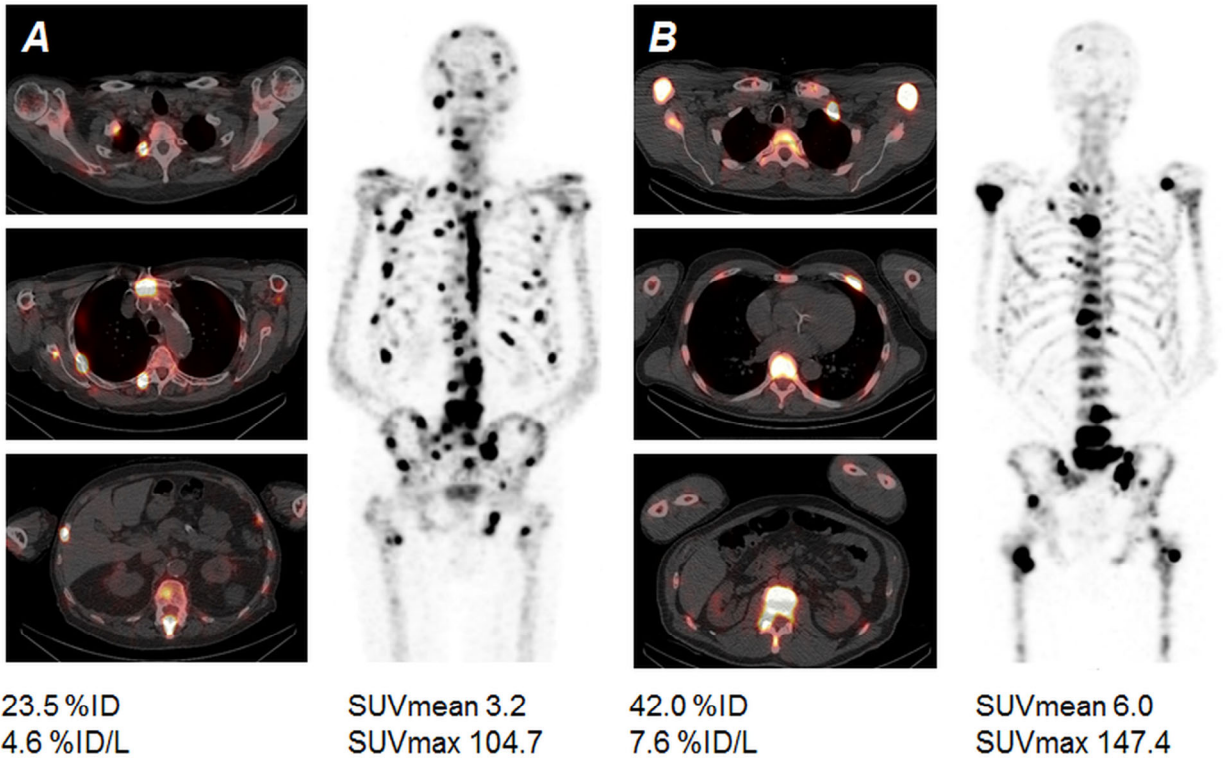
Typical case studies in two patients with disseminated bone metastasis. Quantitative SPECT/CT revealed low to moderate parameters of ^{99m}Tc -DPD uptake except for pronounced SUVmax in patient A [left] while all measures were markedly high in patient B [right]. Both patients subsequently received 6 cycles of ^{223}Ra . OS survival in patient A (85 y) was 13 months while patient B (72 y) only survived for 7 months after the start of ^{223}Ra .
